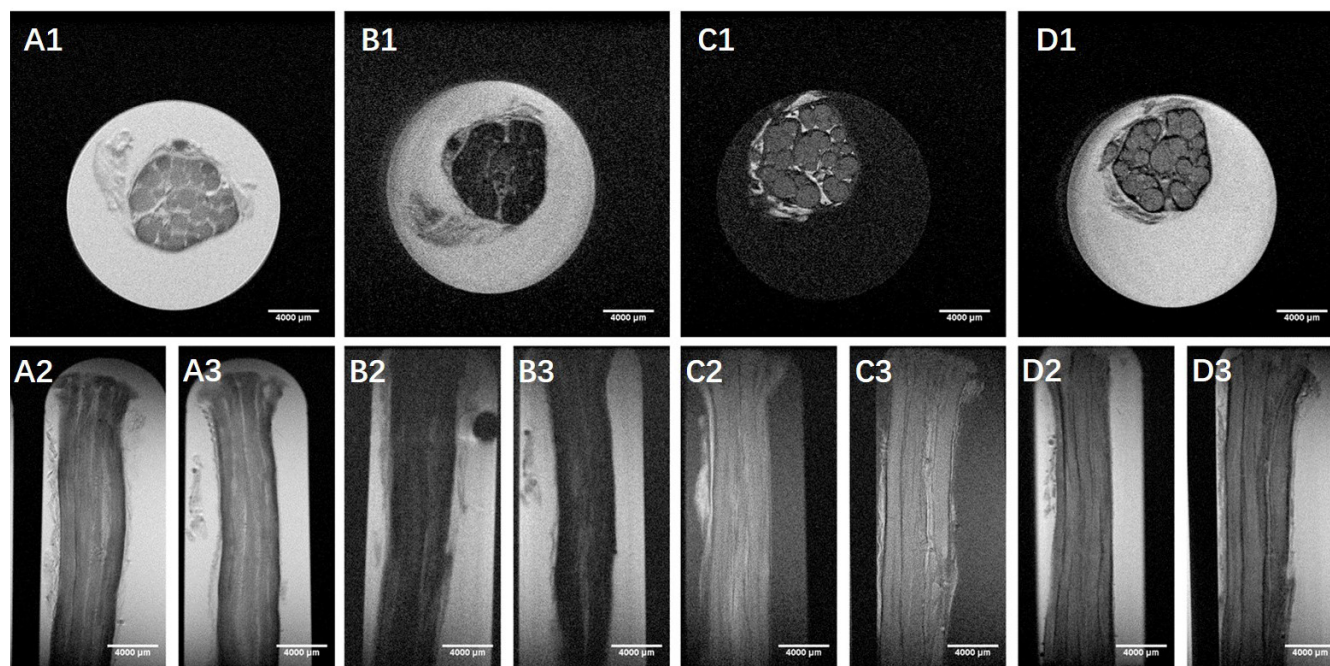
Micro-MRI scanning images.
